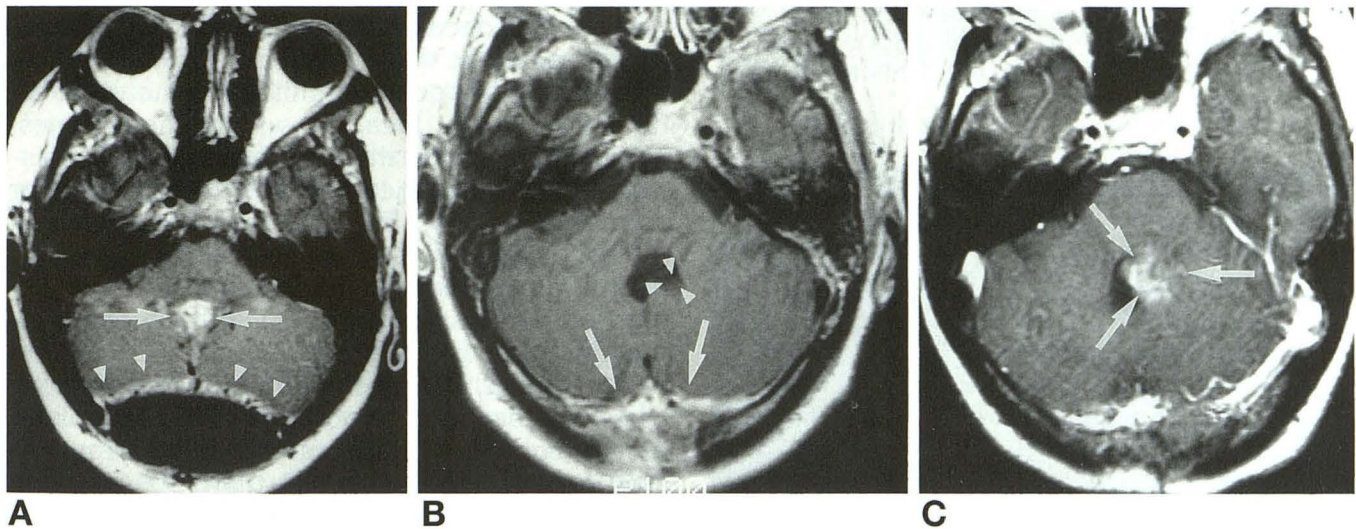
Postoperative MR images of a 13-year-old girl.
